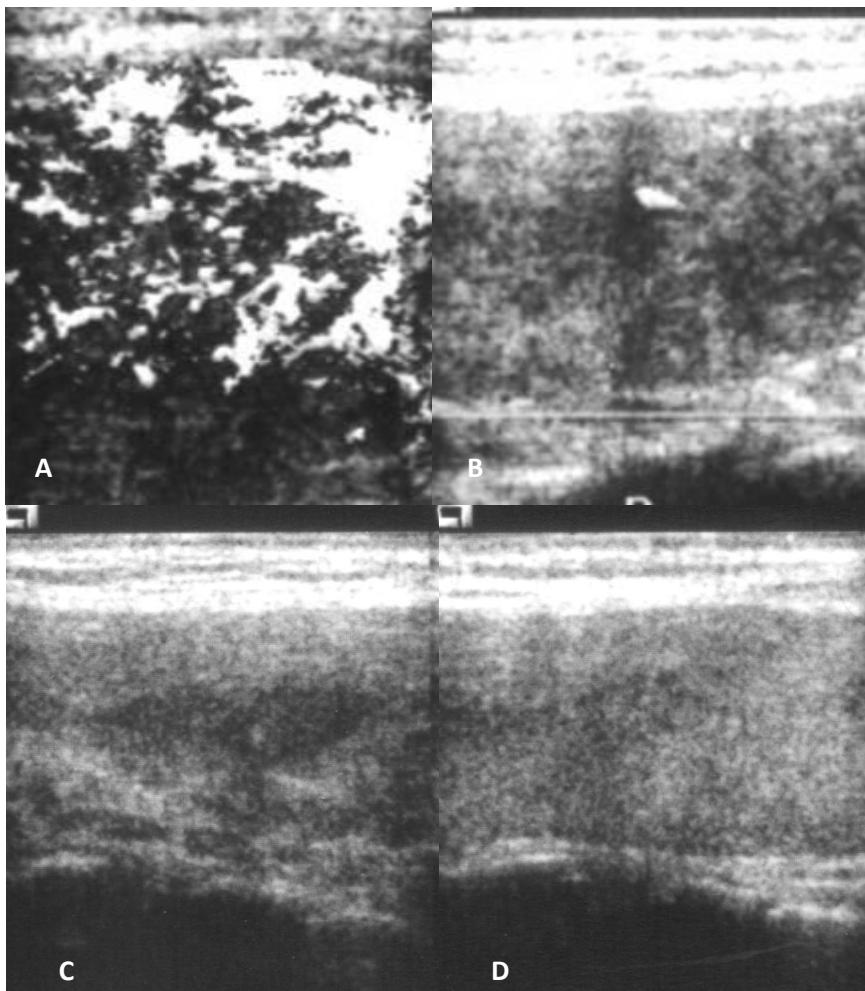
A 31-year-old female with ultrasound examination before and after thyroid arterial embolization. A. Pre-embolization Doppler scan shows abundant blood supply within the thyroid gland consistent with hyperthyroidism. B. Seven days after embolization, ultrasound scan demonstrates that the blood supply within the thyroid has greatly decreased, with some low-level echo areas implying tissue necrosis. C. Six months later, grayscale ultrasound reveals greatly reduced size and blood supply of the gland. D. Ultrasound at 3 years demonstrates decreased thyroid volume with some echo areas, indicating tissue fibrosis of the gland.
